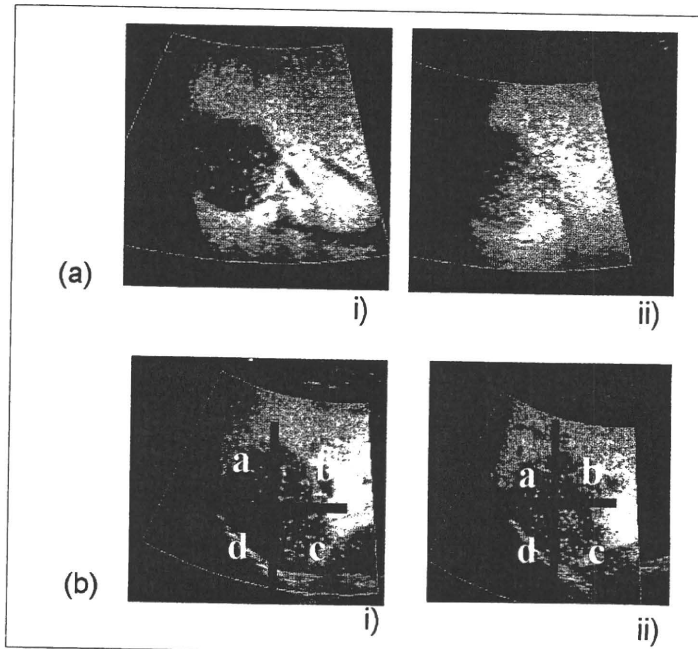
Positive results by solo-phase method and changing posture method in hemangioma. (a) Solo-phase method. i) Liver-specific image after taking early-phase sonograms. ii) Liver-specific image without taking early-phase sonograms. Enhanced area increased by 100% with solo-phase method. (b) Changing posture method. i) Liver-specific image taken in supine position. ii) Liver-specific image taken by changing posture method. The position with maximum enhancement changed from "b" to "c" in this case.
